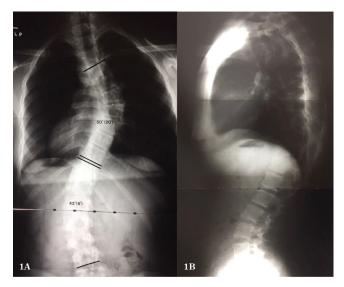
to 1B. AP and lateral pre-operative long standing X-rays. A Lenke type I 50° curve with a thoracolumbar kyphosis of 22° and a lumbar modifier C.
